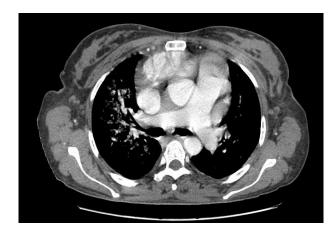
Chest CT angiogram showing cardiomegaly with pulmonary arterial hypertension.
